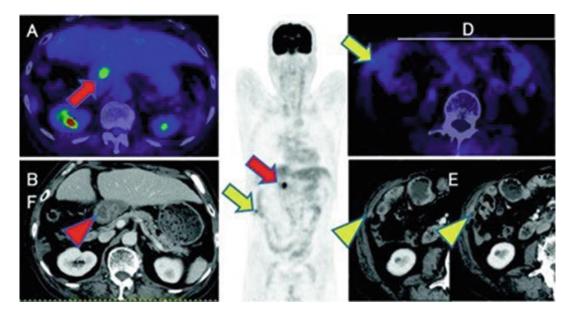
Postoperative common bile duct cancer patient with CA19–9 elevation. Abnormal $[^{18}F]FDG$ accumulations are shown at hepatic hilum (a, c; *red arrows*) and intra-abdominal space (c, d; *yellow arrows*). So these are highly suspected recurrent lesions including local
